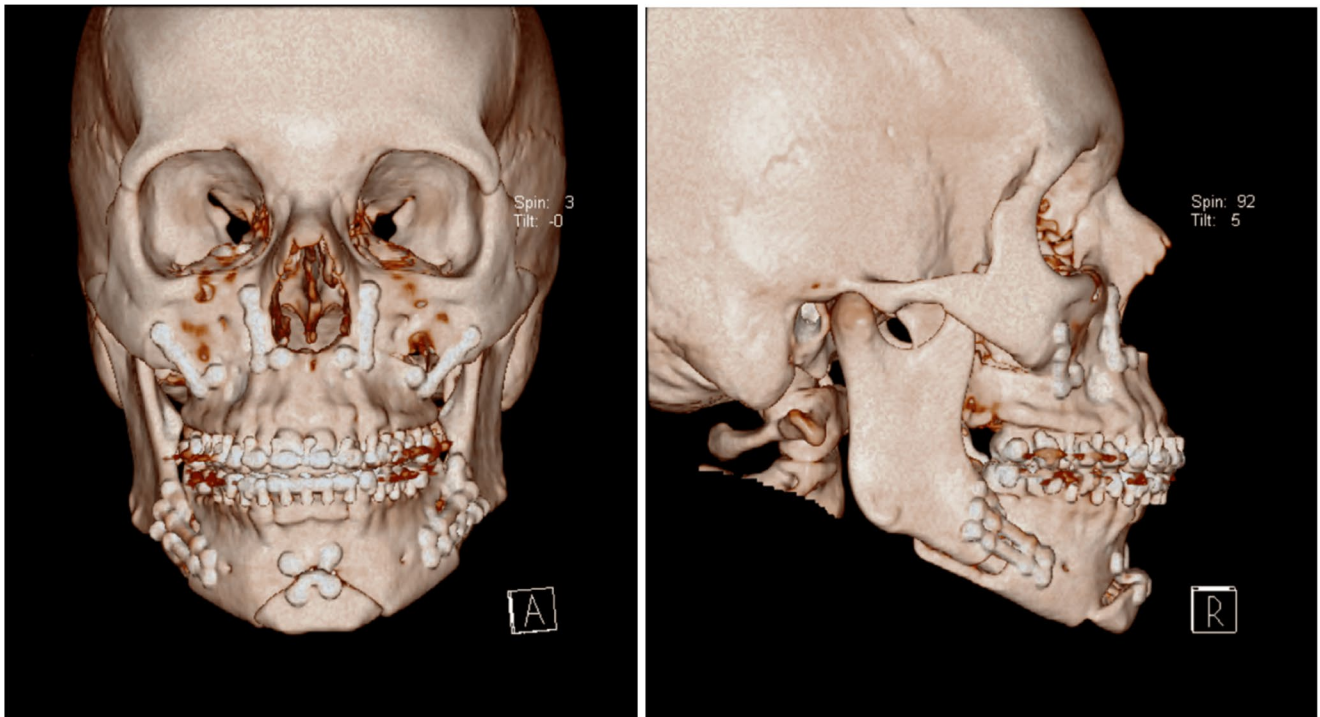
Postoperative CT scan in frontal and lateral profile evidencing the final result.
